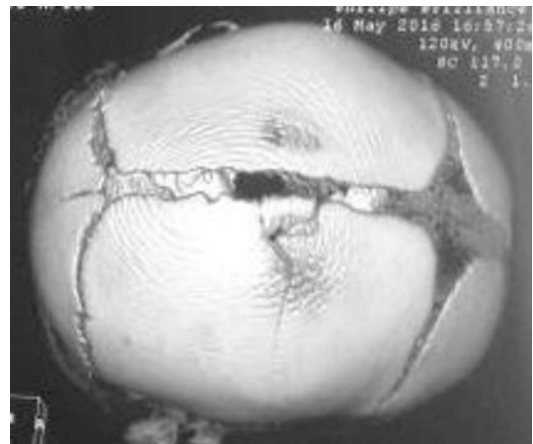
CT scan showing linear undisplaced fracture of the right parietal bone extending into the sagittal suture
